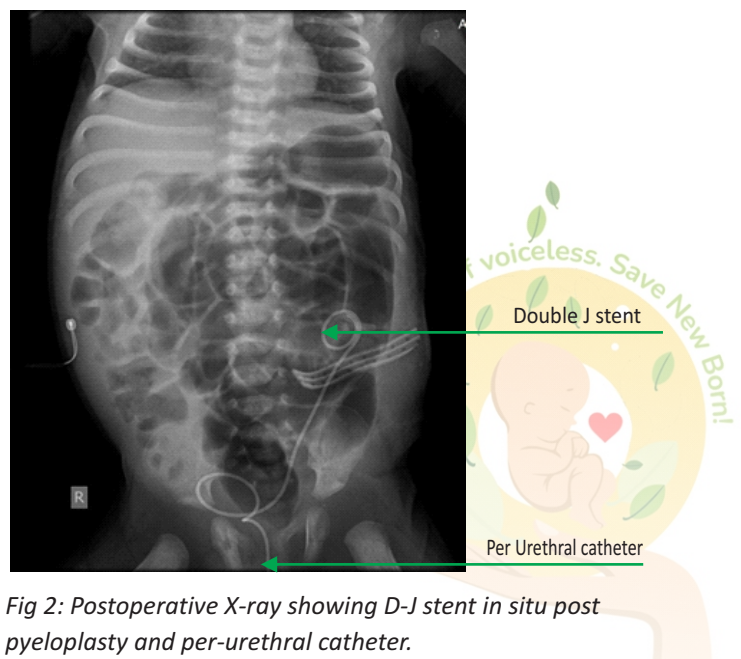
Postoperative X-ray showing D-J stent in situ post pyeloplasty and per-urethral catheter.
